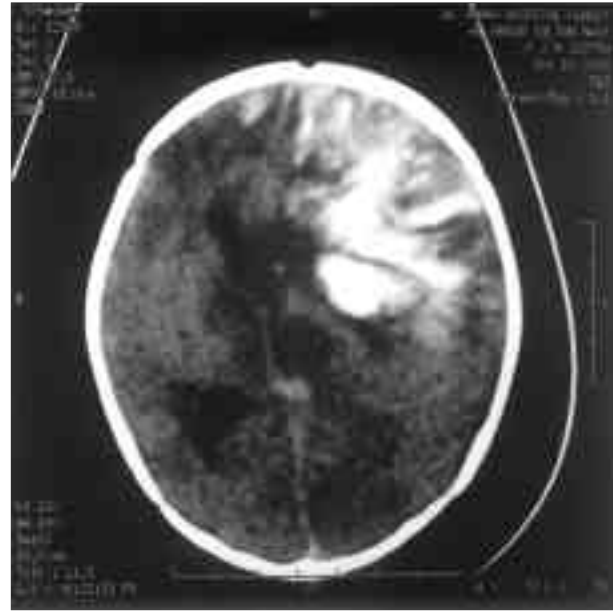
CT Head showing intracerebral hemorrhages in left frontoparietal and right frontal lobe 48 hours after admission.
